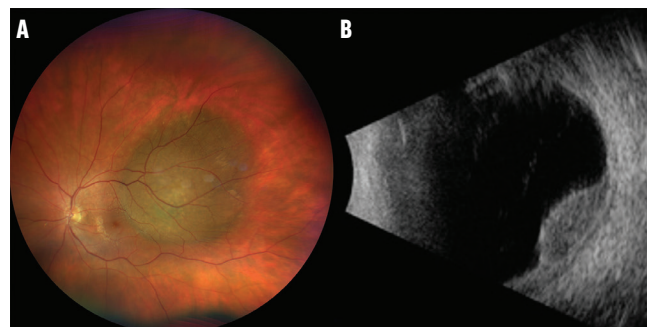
The choroidal melanoma (A) was 5.7 mm in thickness on ultrasonography (B).
